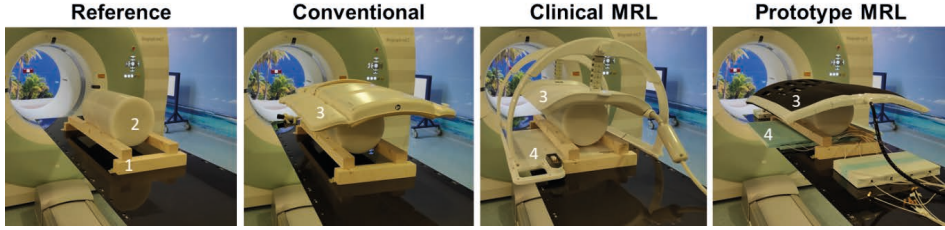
Setup of the PET/CT measurements. A wooden frame is positioned (1) on which the cylindrical source (2) is placed. Anterior (3) and posterior (4) elements could be placed without position changes of the source. The reference scan is performed without a receive array present. The anterior element-only setups of the clinical MRL and prototype MRL arrays are not shown but were also tested.
